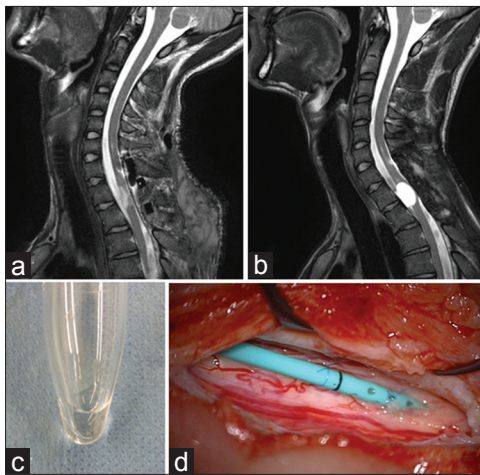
(a, b) T2-weighted magnetic resonance images at 1 day (a) and 10 months (b) after the first surgery. (c) Contents of the cyst. (d) Intraoperative photograph of the second operation showing a cyst-subarachnoid shunt tube inserted into the cyst
